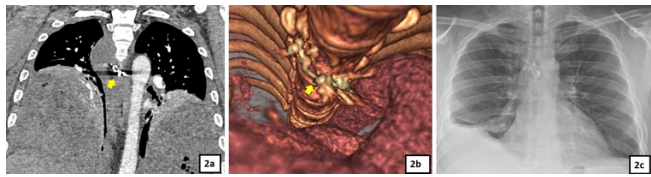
The coil in embolized intercostal aneurysmatic dilatation arising from the descending aorta (arrow) (Coronal plane tomography section) (a), 3-D view of coil in the embolized aneurysmatic dilatation (arrow) (b), chest radiography on the 180th day after discharge (c).
